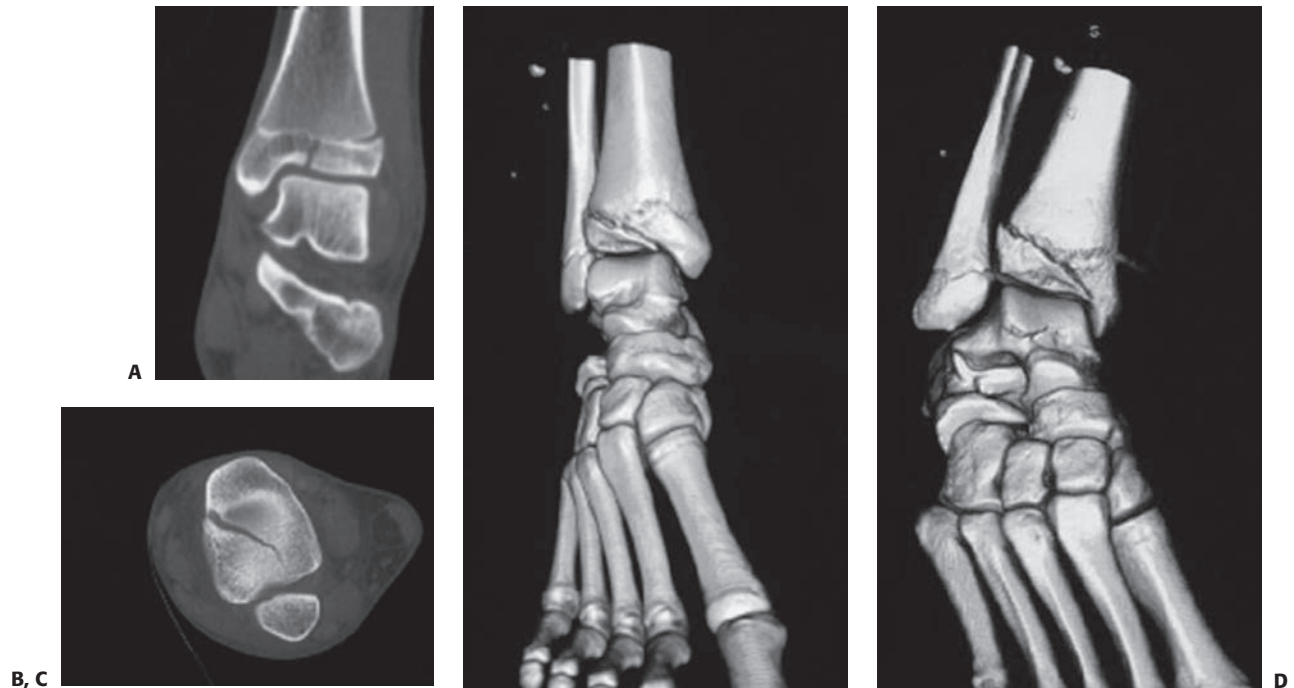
Three-dimensional CT reconstruction of juvenile Tillaux fracture. A: Coronal CT image of minimally displaced juvenile Tillaux fracture. B: Sagittal CT image of minimally displaced juvenile Tillaux fracture. C, D: Three-dimensional reconstruction of juvenile Tillaux fracture.
